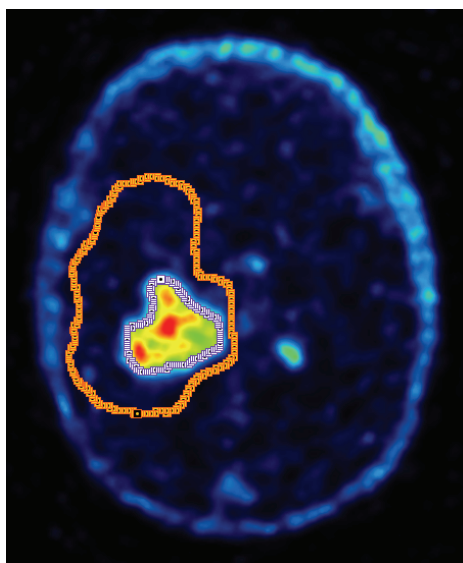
Automatic delineation of the metabolic tumor volume (MTV). The MTV was delineated on a 5-min PET image acquired 25-30 min post-injection applying a threshold of 40 % SUV_{max} (purple) within the 95 % isodose (orange) (patient 4).
